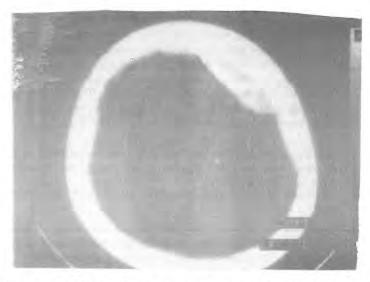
Preoperatif CT showing hyperdens mass on frontoparietal region.
